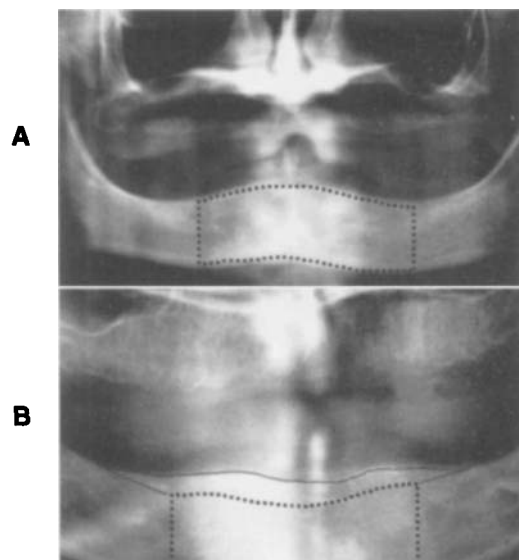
■ Preoperative radiographs. Mandibles marked to outline available bone (A) and area requiring ramping to obtain adequate ridge width (B).
